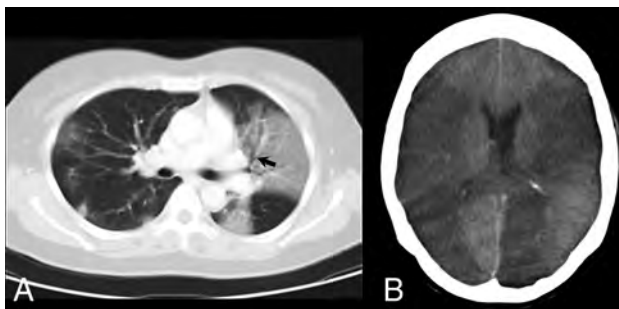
Patient with SARS infection. A, Axial 10-mm-section portable chest CT scan shows multifocal and confluent ground-glass opacities bilaterally with air bronchogram (arrow) in the left upper lobe. B, Axial CT scan of the head shows extensive low-attenuation cerebral infarction involving bilateral middle cerebral and left posterior cerebral artery territories.
